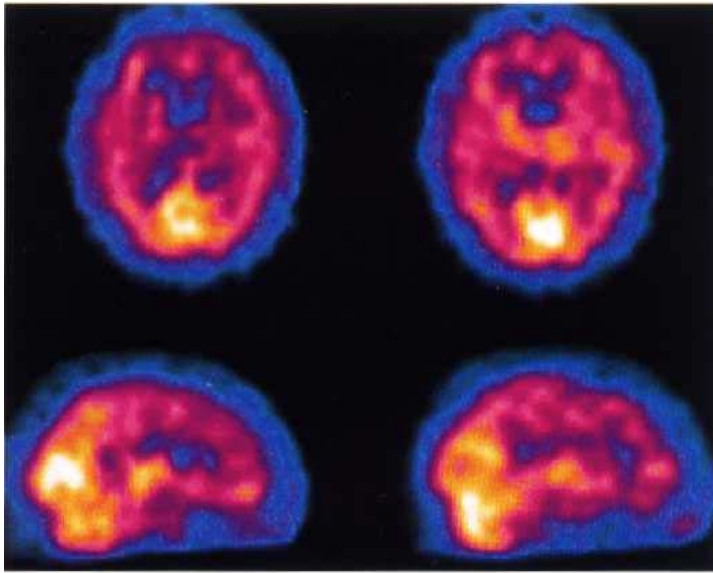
^{99m}Tc-exametazime brain SPECT: axial (top row) and left and right parasagittal (bottom row) sections in a patient with dementia of frontal lobe type. Note the marked frontal and temporal ischaemia with central atrophy as well.
